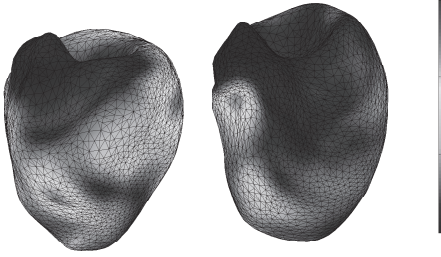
(color version on page 157): Two end-diastolic left ventricle shapes with color-coded landmark uncertainty [0-15 mm], derived from CTA data by multi-atlas segmentation.
